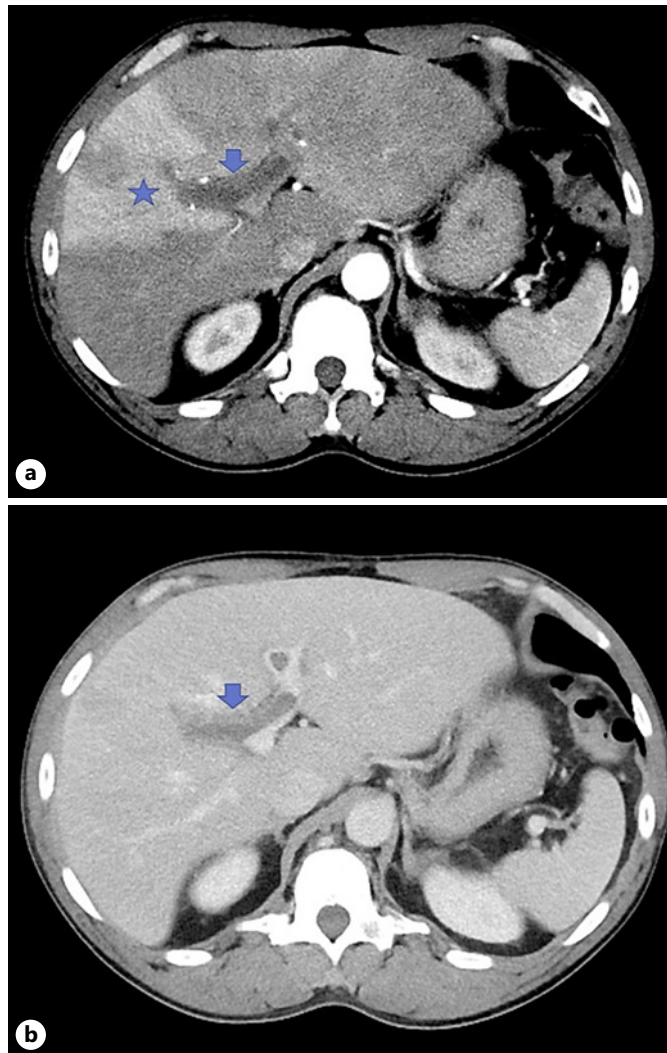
a Triple-phase liver CT (arterial phase, axial) demonstrates a well-demarcated filling defect (arrow) straddling right and left portal veins (right more occlusive than left). Secondary to the hepatic dual vascular supply, there is a large, sectorial wedge-shaped region of right anterior (segment V/VIII) parenchymal hyperenhancement (star), or transient hepatic attenuation difference. b On the portal venous phase, this area becomes relatively isodense to liver parenchyma. The venous filling defect (arrow) does not change in its low attenuation appearance.
